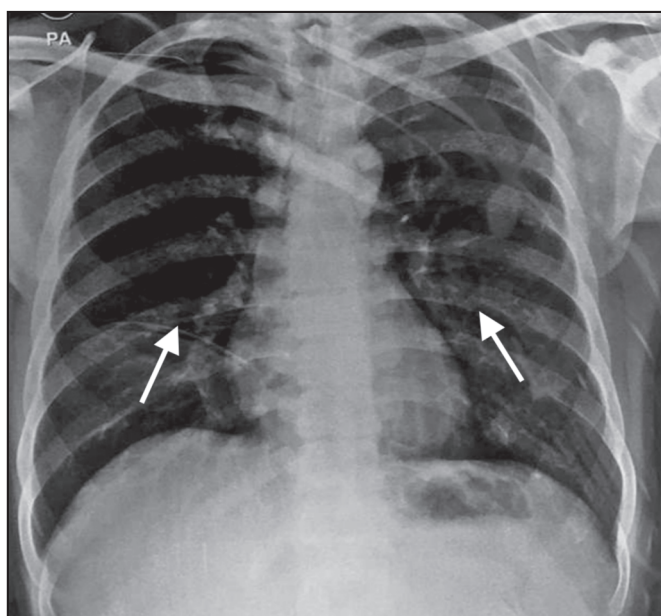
Chest X-ray showed bilateral infiltrates.
